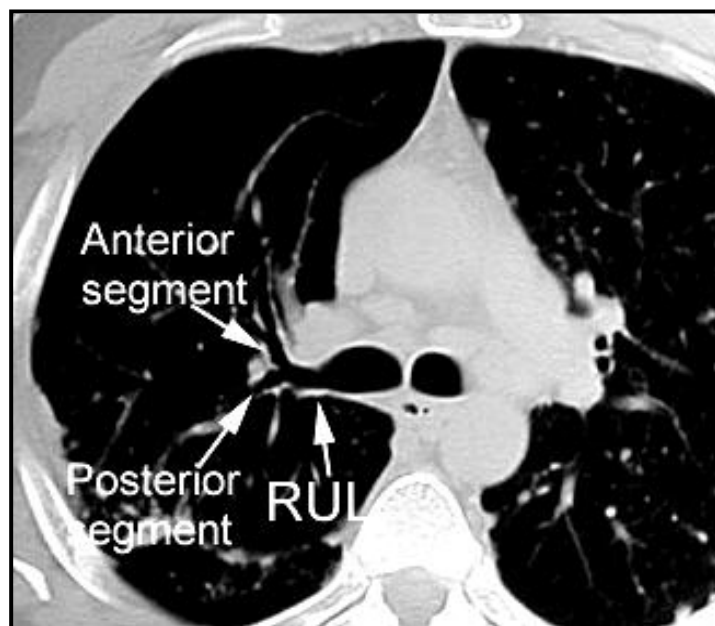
axial CT cuts of the segmental branches of the right main bronchus (*Gruden et al., 2000*)
